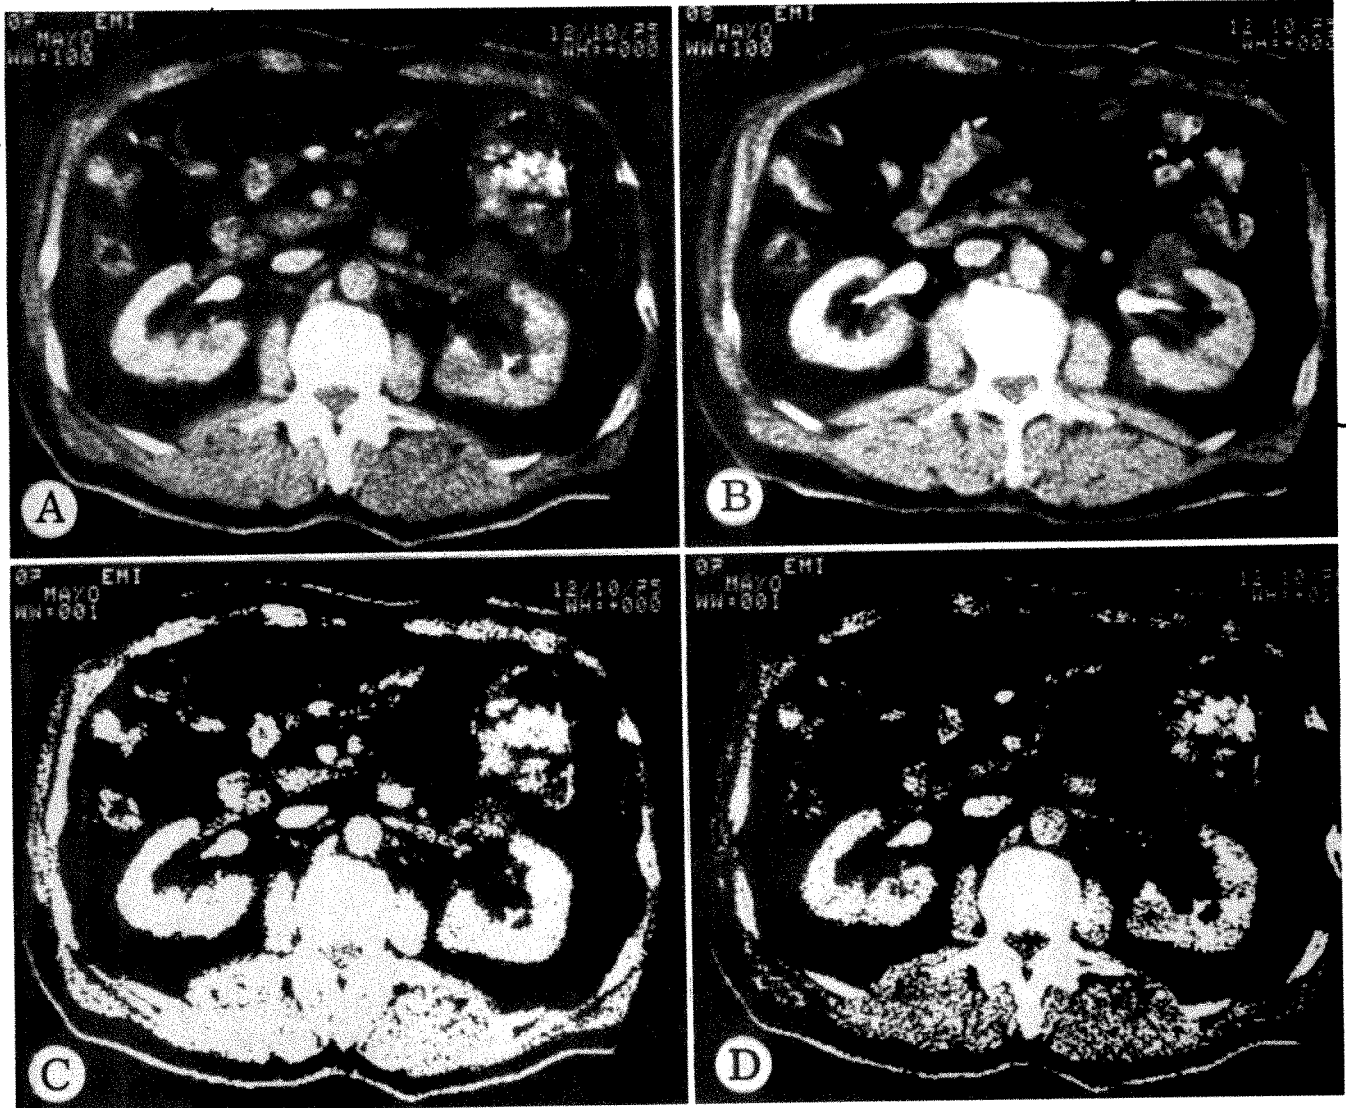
CT scans of 59-year-old man with nephrotic syndrome and blood smear findings consistent with retroperitoneal lymphoma. A–D. Selected tomographic cuts through retroperitoneal space from level of pancreas to midpelvis. Abundant fat planes clearly demonstrate normality of patient's retroperitoneal space.
